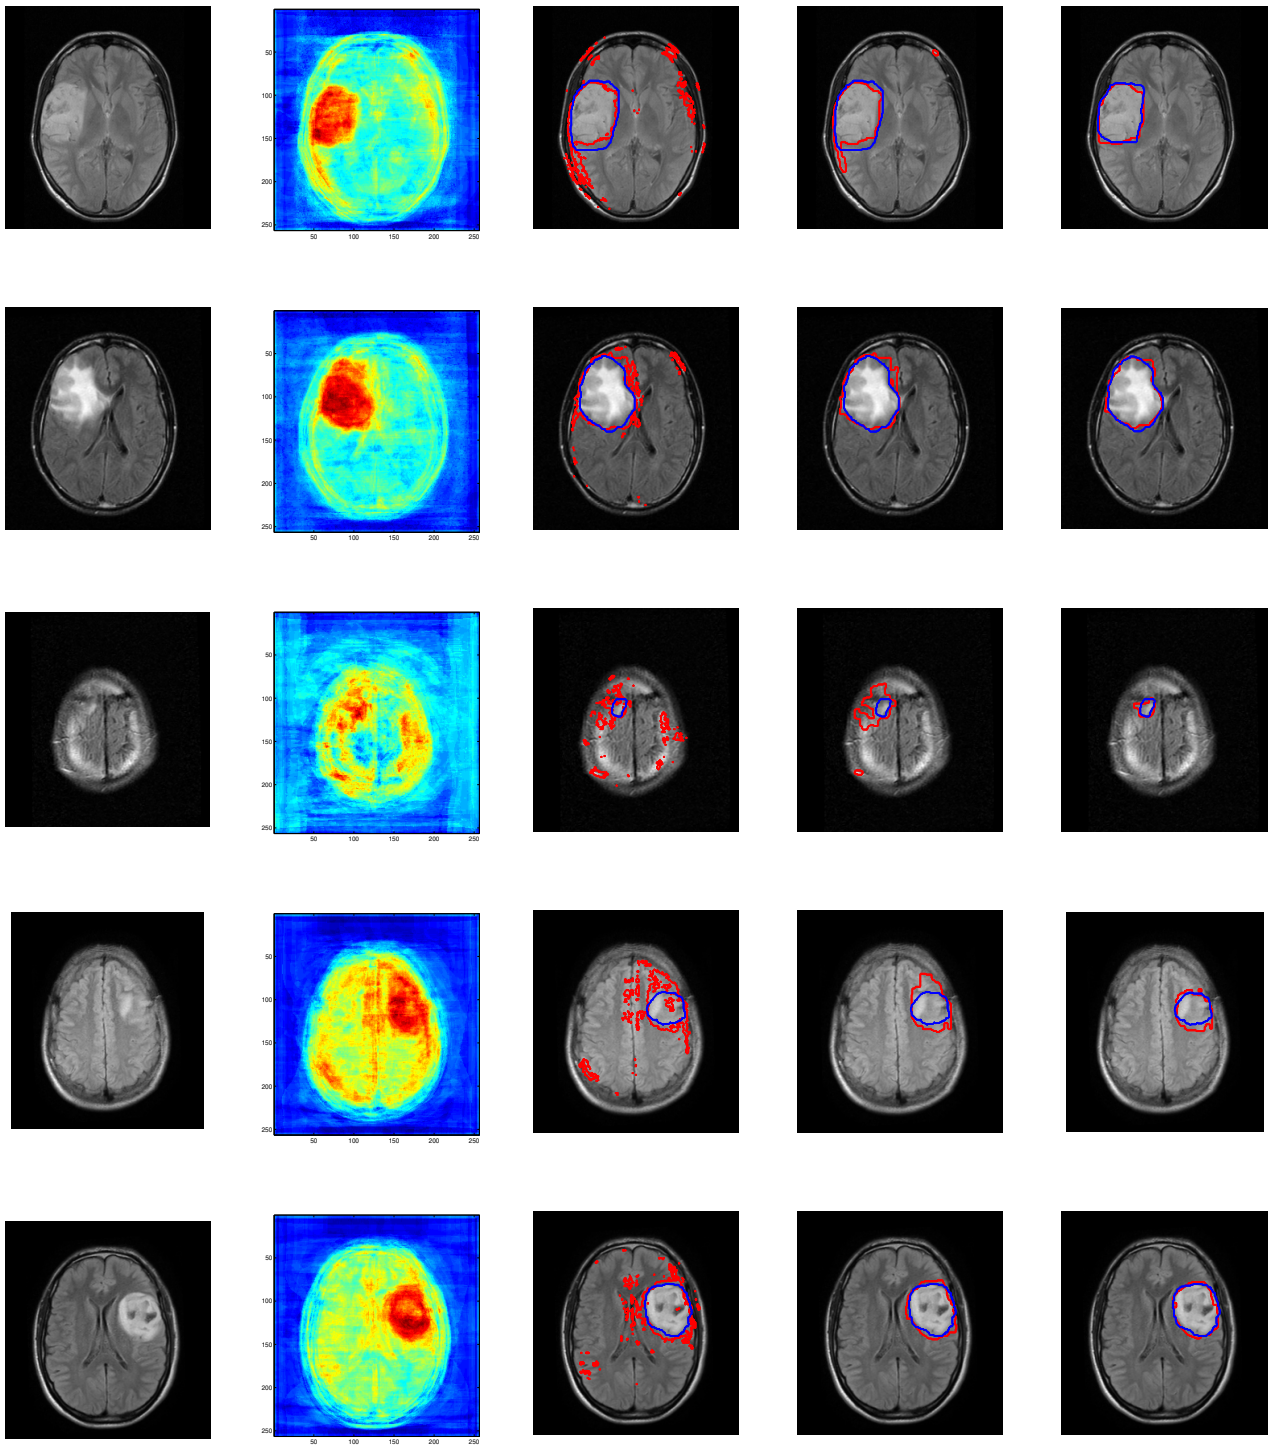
Various stages of segmentation. Original MRI image (a), Boosting score (b), Segmentation using boosting only (c), pairwise regularization (d) and spatial prior (e). The manual segmentation map (blue) is superimposed to the automatic segmentation (red)
